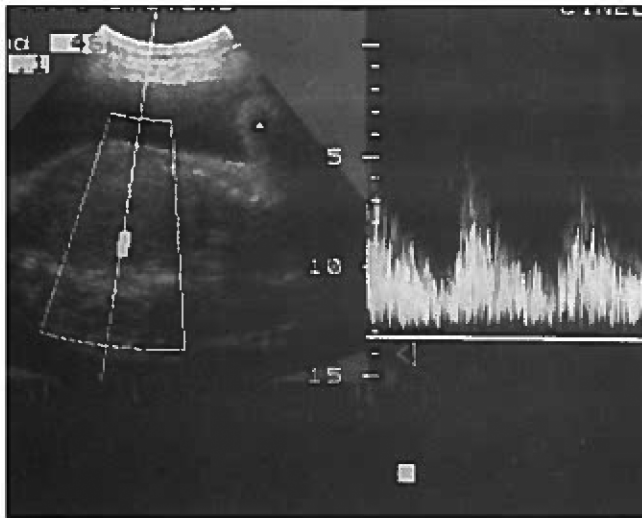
Doppler sonogram of the mass shows increased diastolic flow.
